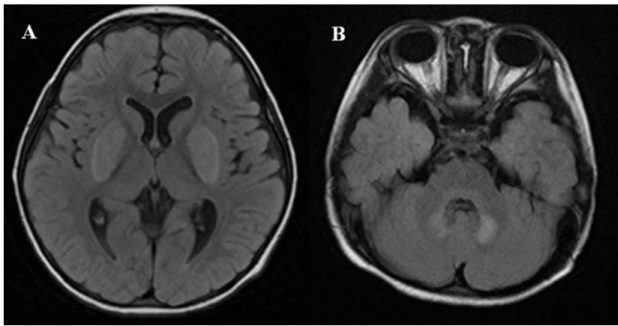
MR images of case 2 and case 3 during the acute phase. 1A) Case 2: A 2-year-old girl suffered from conscious disorientation, unstable gait and respiratory failure upon admission. T1-weighted images showed symmetrical high signal intensities in the putamen, globus pallidus, midbrain and cerebellum. 1B) Case 3: A sibling of case 2 suffered from occasional unstable gait at the age of two years old. T1-weighted images showed symmetrical high signal intensities in the cerebellum, pons and preserved basal ganglia.
